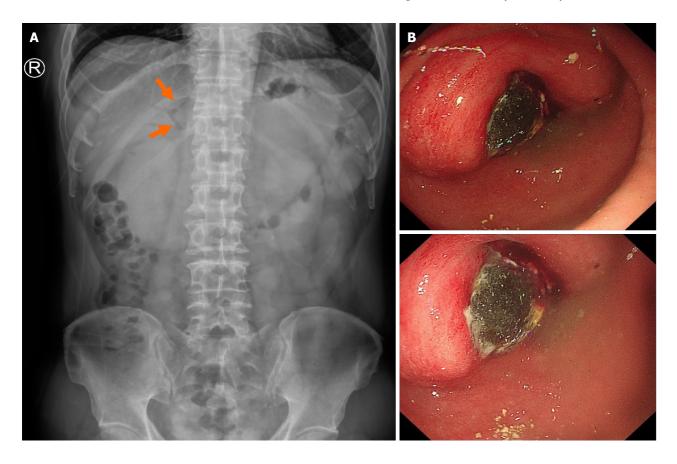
X-ray and Endoscopic findings. A: Abdominal X-ray image showing pneumobilia of the intrahepatic and extrahepatic bile ducts (arrows); B: Endoscopy revealing a large gallstone in the gastric pylorus leading to gastric outlet obstruction.
